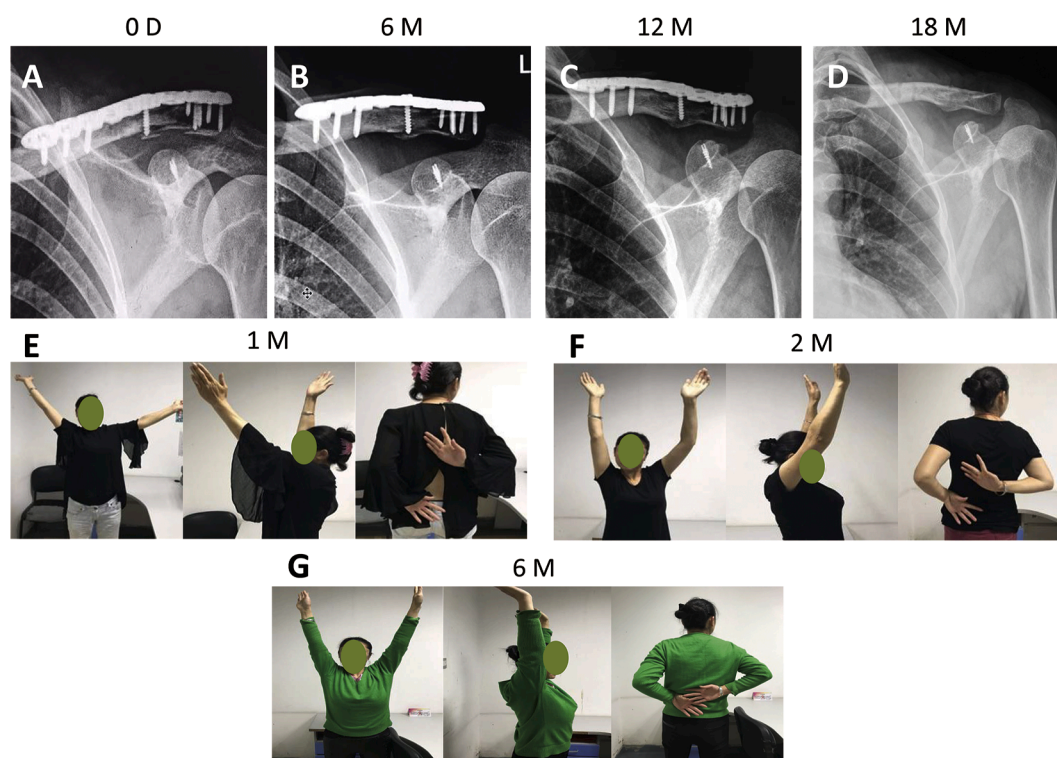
A 49-year-old female patient with left distal clavicle fracture (Neer type V) caused by falling. (A) X-ray image taken immediately after surgery. (B and C) Postoperative X-ray images at 6 and 12 months after operation. (D) X-ray image after the removal of plate fixation 18 weeks post-surgery. (E–F) Clinical photographs of shoulder joint function at 1, 2, and 6 months after surgery.
